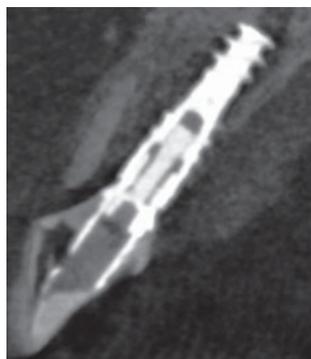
CBCT image of the implant immediately following surgery.
